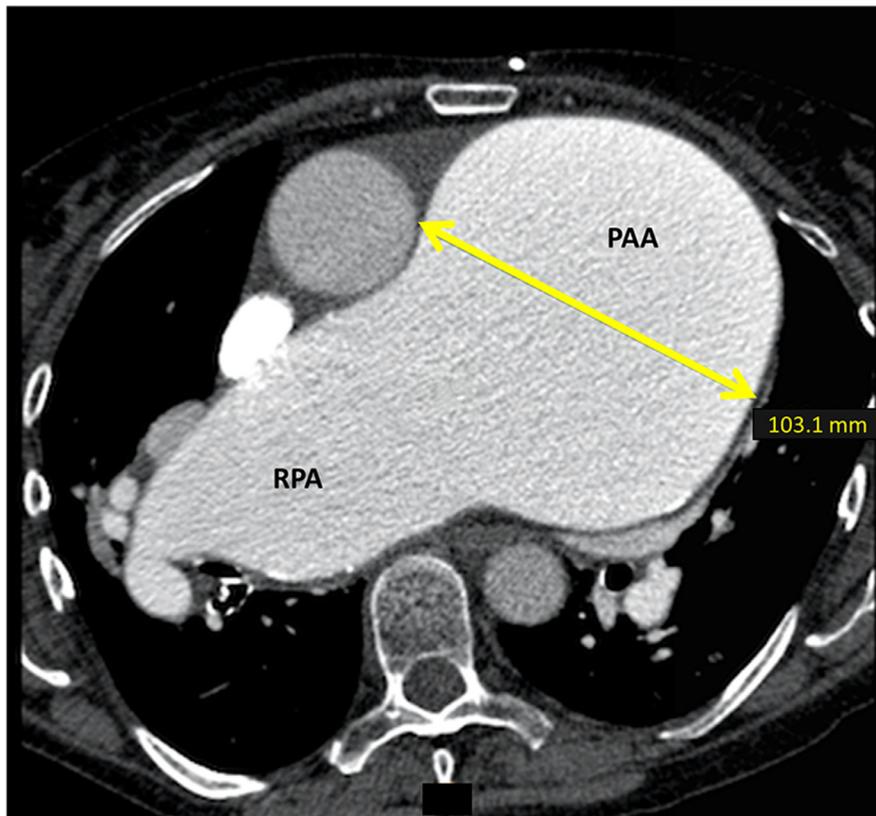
CT angiography axial view of a giant PAA with concomitant dilatation of the right pulmonary artery. PAA = pulmonary artery aneurysm; RPA = right pulmonary artery.
